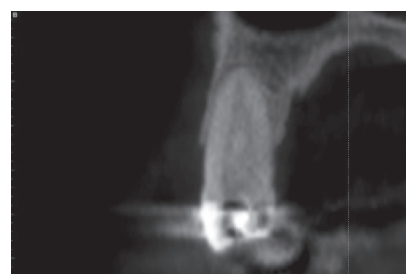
Thin buccal plate and sufficient bone apico-palatal to the root on the CBCT image.
